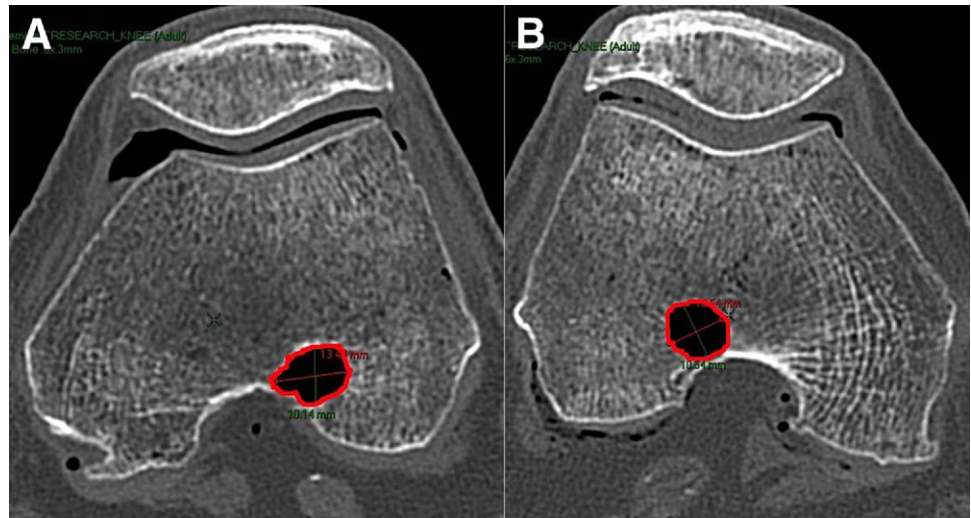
CT images of femoral tunnel aperture: (A) medial arthroscopic drilling and (B) transtibial drilling.
